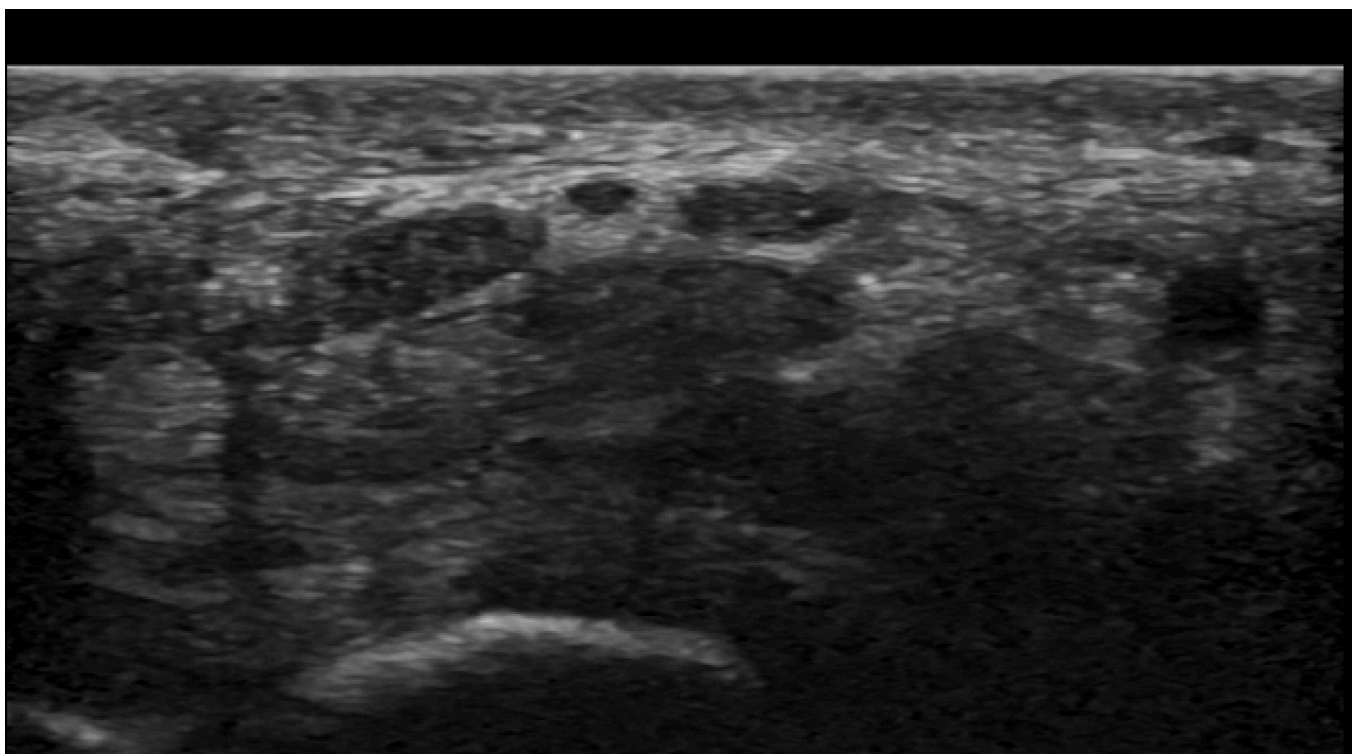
Disparité de calibre du nerf médian à l'entrée du canal carpien. Coupe échographique axiale (A, B) et sagittale (C). Hypertrophie du nerf médian (flèches blanches) mesurée à 19 mm² de surface de section en amont du rétinaculum des fléchisseurs (petites flèches blanches) avec diminution de calibre (têtes de flèche blanches) sous le ligament transverse du carpe. Le nerf est par ailleurs le siège d'une hyperhémie au Doppler énergie (flèche orange). Il n'y avait pas d'anomalie des tendons fléchisseurs sous-jacents (*).
